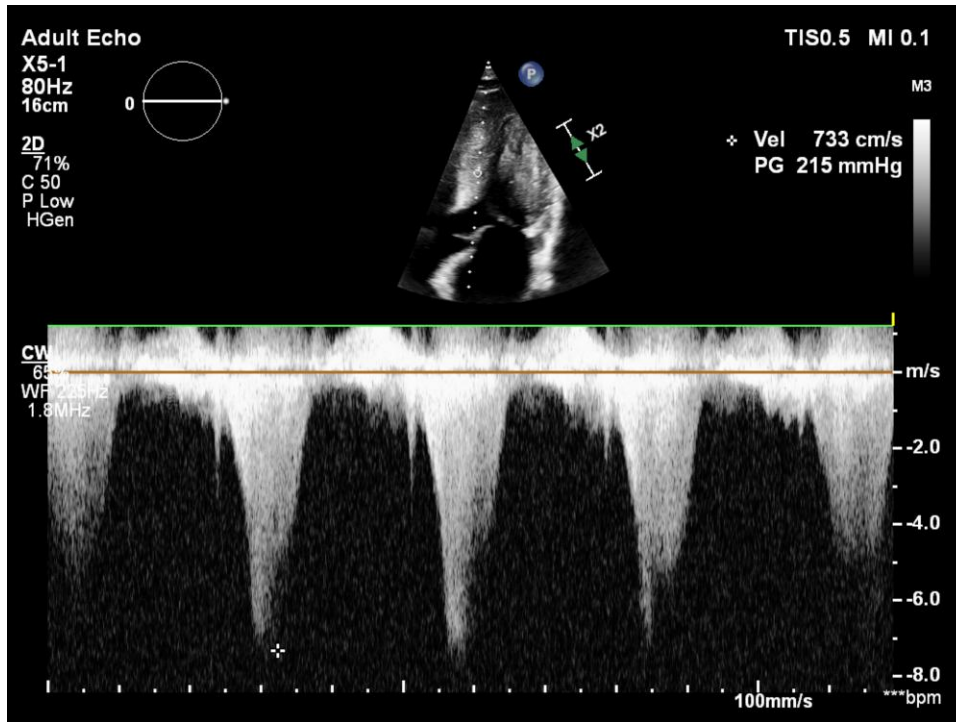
Transthoracic echocardiography—pre-procedural maximum left ventricular outflow tract gradient.
